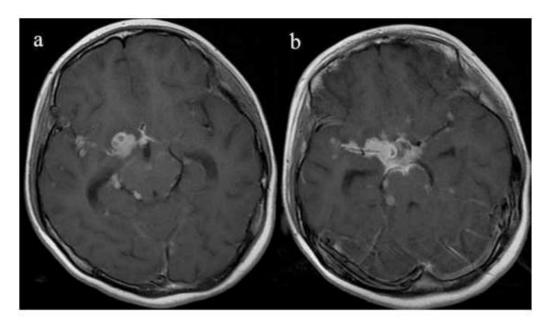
Axial contrast enhanced T1 Weighted MR images showing multiple tuberculomas with accompanying meningitis⁵⁸
